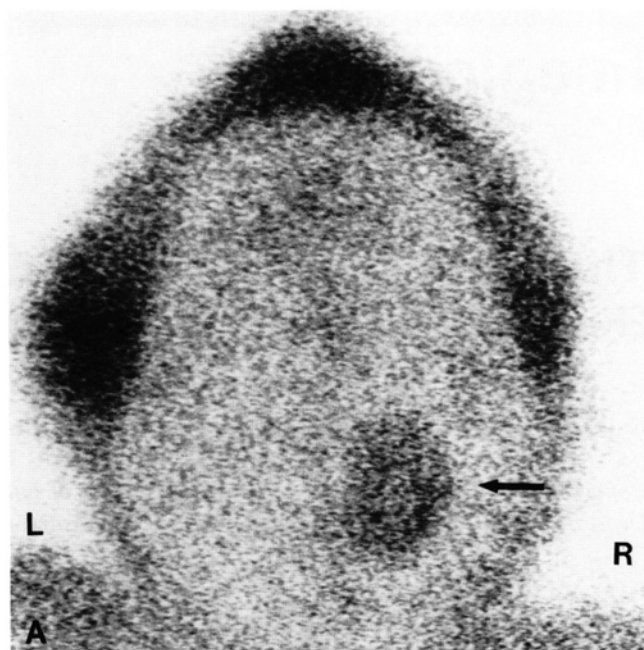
(A) Baseline planar vertex image showing ^{201}Tl uptake in tumor (arrow). (B) Baseline contrast enhanced CT scan at the level of tumor (arrow).
